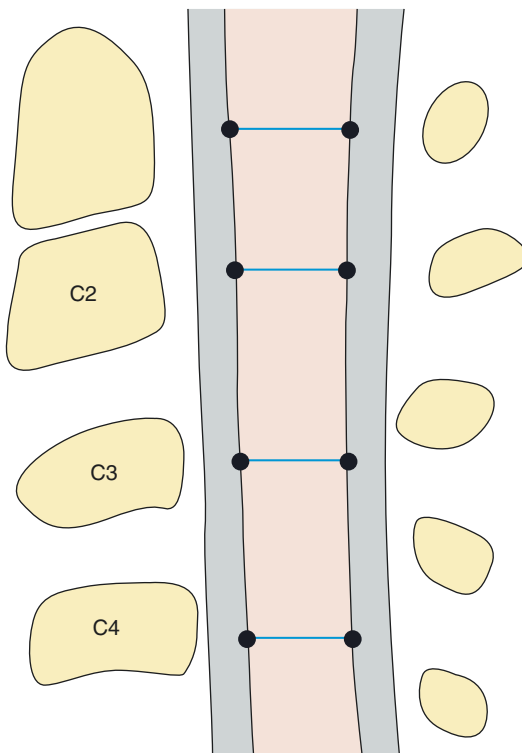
Adult spinal cord AP diameter on MRI. AP diameter is measured from anterior aspect to posterior aspect of the cord, in the midsagittal plane, perpendicular to long axis of the cord
